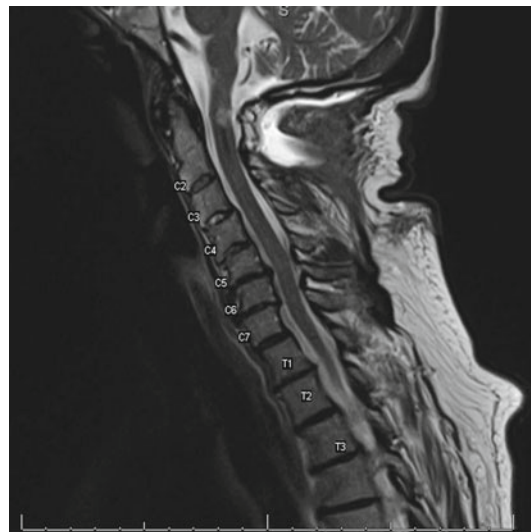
T2-weighted MRI showing a cavernous malformation. Vertebral levels C2–T3 are indicated
